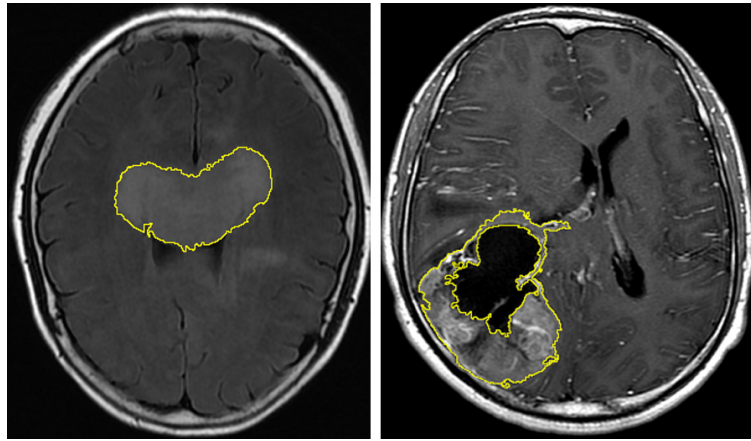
Representative cases for the definition of volume of interest in anatomical images. Note: Two representative cases of low-grade gliomas and high-grade gliomas are displayed above to clarify the definition of volume of interest (VOI). With the help of a semi-automatic method based on the threshold of MRI signal intensities, three-dimensional VOIs were segmented first according to signal intensities mainly on T2FLAIR and contrast-enhanced T1-weighted images to depict the general location of the tumour. Then, the obtained tumour areas were adjusted by an experienced radiologist. Moreover, diffusion weighted images, i.e., b1000 map was used to avoid necrotic and cystic areas. The three-dimensional VOIs were carefully drawn on the tumour parenchyma with all anatomical images and diffusion images to reduce the interference of necrotic and cystic areas and haemorrhage.
